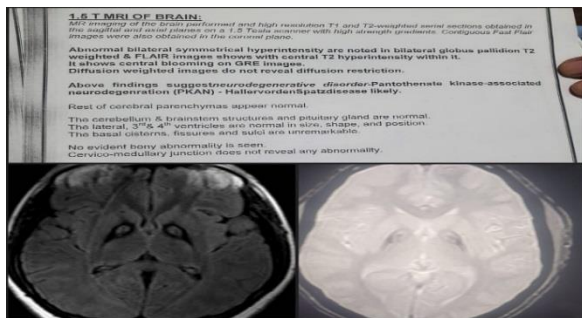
MRI showing symmetrical hypointensity in the globus pallidus and posterior limb of the internal capsule.
